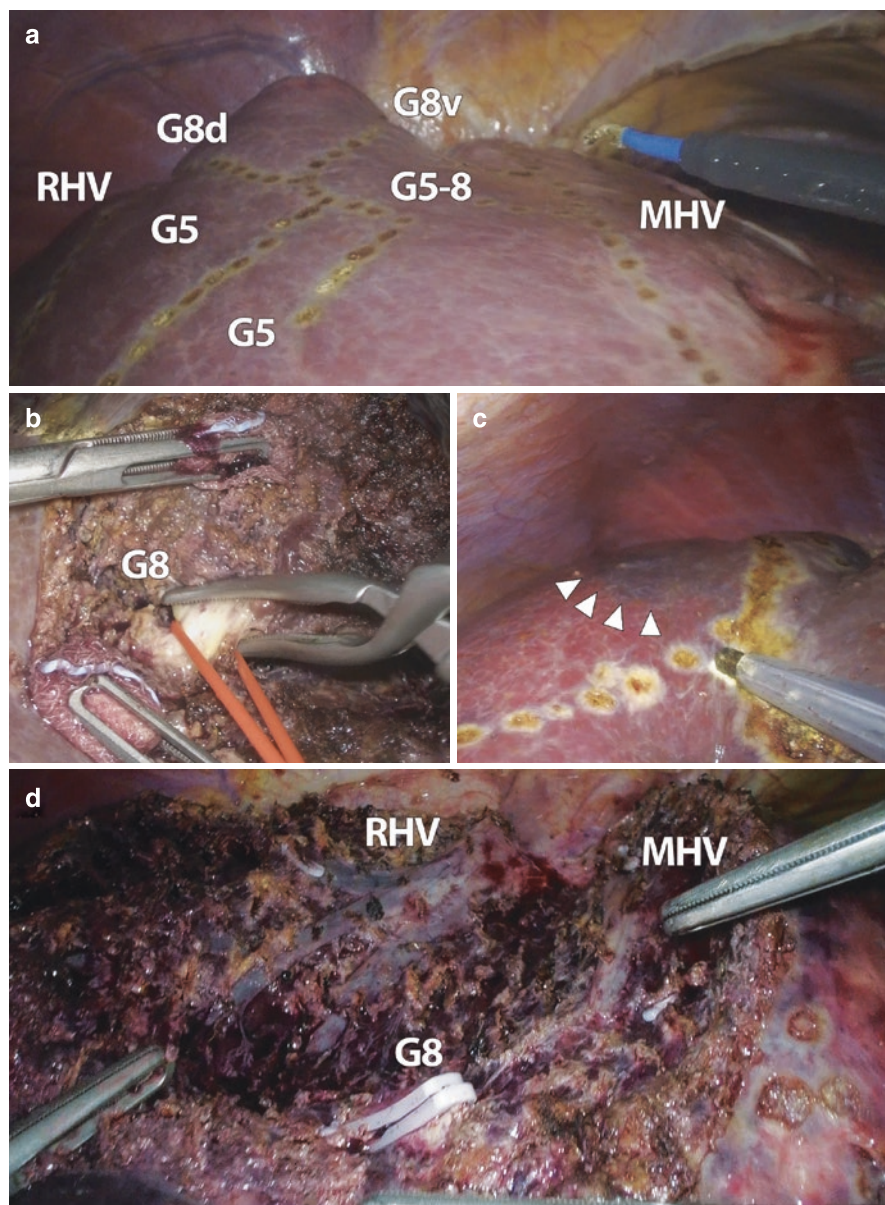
Ultrasound-guided anatomical segment 8 resection. (a) The sketch of all the landmarks is completed: middle (*MHV*) and right (*RHV*) hepatic veins, the anterior glissonean pedicle (*G5–8*), Sg8 dorsal (*G8d*) and ventral (*G8v*) glissonean pedicles and segment 5 (*G5*) glissonean pedicles. (b) G8 is dissected along the cut surface and clamped. (c) Sg8 ischemic demarcation line (arrow-heads) is clearly visible. (d) Sg8 segmentectomy is completed: *MHV*, *RHV* and G8 stump are visible on the cut surface
